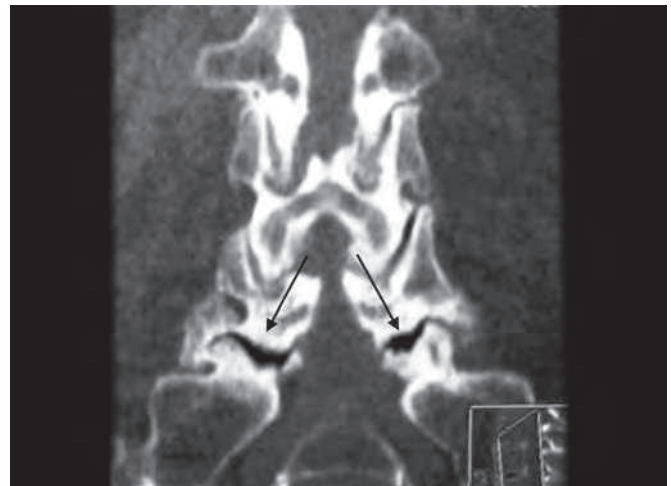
Computed tomography images of facet joint arthropathy on coronal view. Arrows point to facet joint arthritis.
